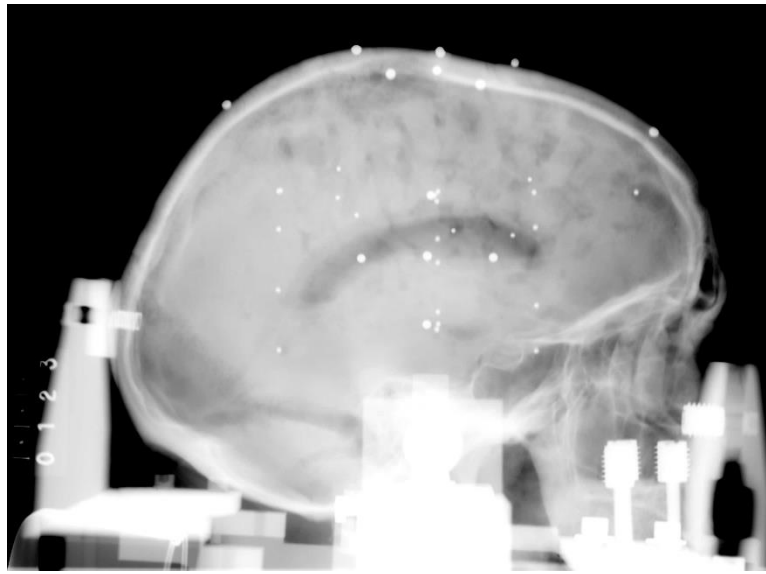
Plain x-ray of the brain and skull targets in NDTB.
